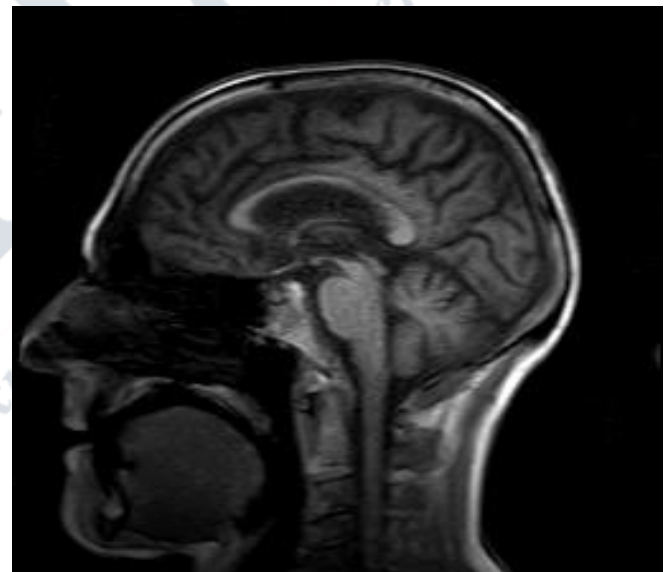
MRI Brain – nil significant radiological findings for PSP
